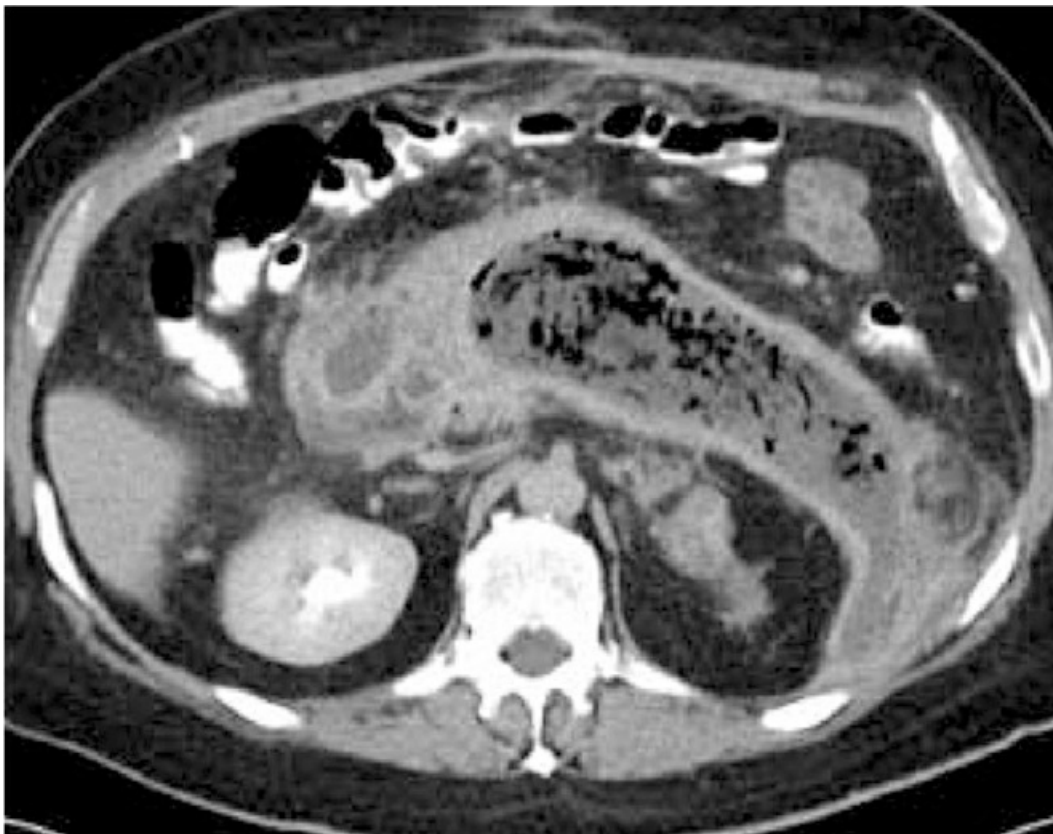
Contrast-enhanced CT image showing extensive necrosis of the pancreas with numerous gas bubbles, indicating infection.
